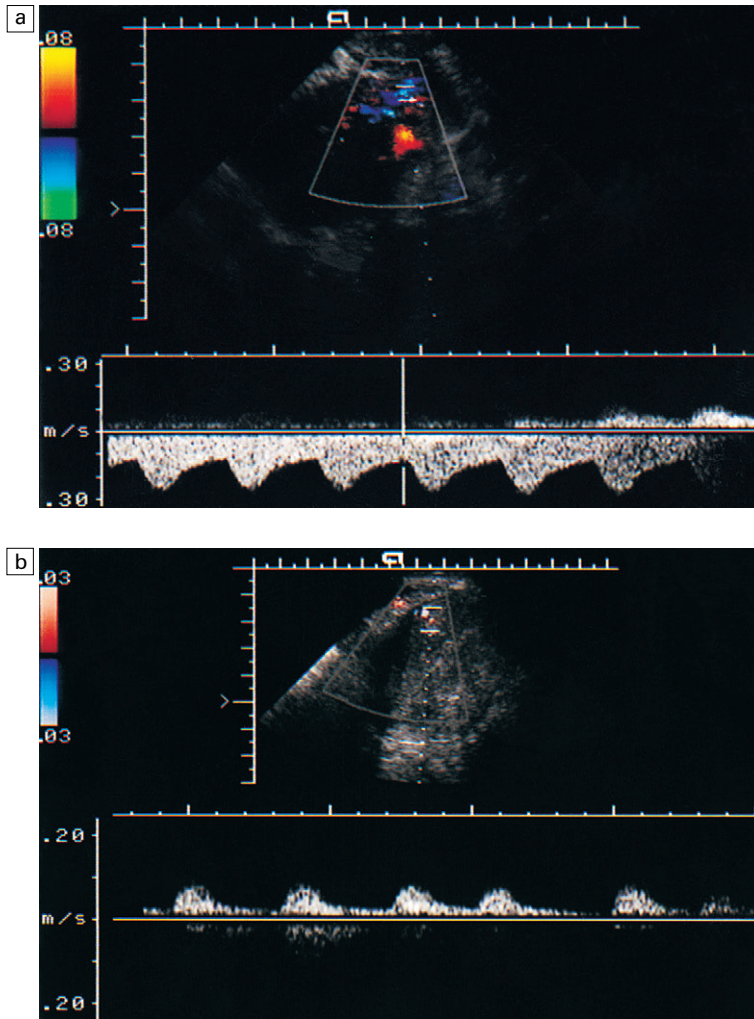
(a) Spectral Doppler of uterine artery demonstrating increased uterine blood flow in patient on tamoxifen. (b) The return of uterine blood flow to normal values after withdrawal of tamoxifen.
